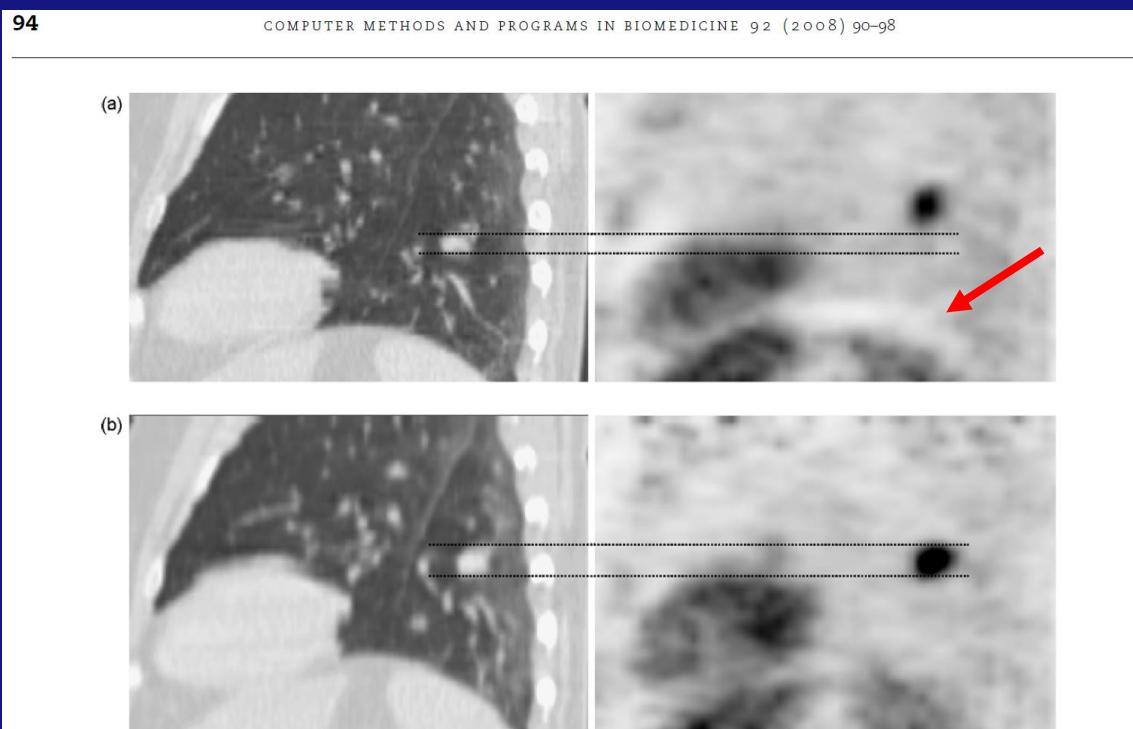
Sagittal cross-sections of images from Patient 1 for (a) CT-std (left) and Ungated PET (right) images and (b) BH-CT (left) and BH-CT-based PET (right) images. Dotted lines are placed on the upper and lower boundaries of the lesion on the CT images and carried over onto the corresponding PET image. Cardiac motion artifacts are visible on both CT images because no cardiac gating was performed.
